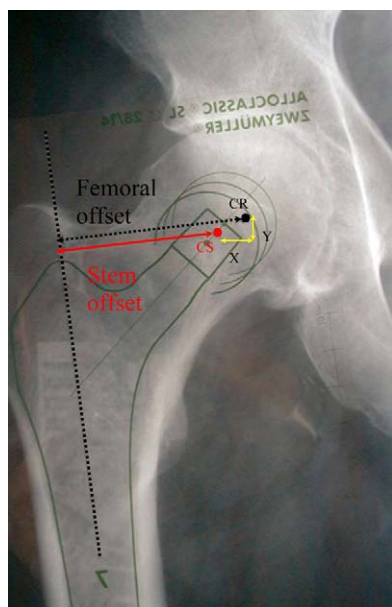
Template on X-ray showing the method of measuring variation in offset (X vector) and in limb length (Y vector) between the center of rotation of the hip (CR) and the center of the femoral head of the stem (CS). The center of rotation of the hip was determined taking account of the usual slight medialization of the cup [19,20]. Templates for the five kinds of stem were successively applied and digitized. Stem size and position were chosen so as to fill the femoral canal while conserving offset and limb length so far as possible. An independent observer (H.A.) measured variations in length and offset, using Imagika™ software on the digitized views.
